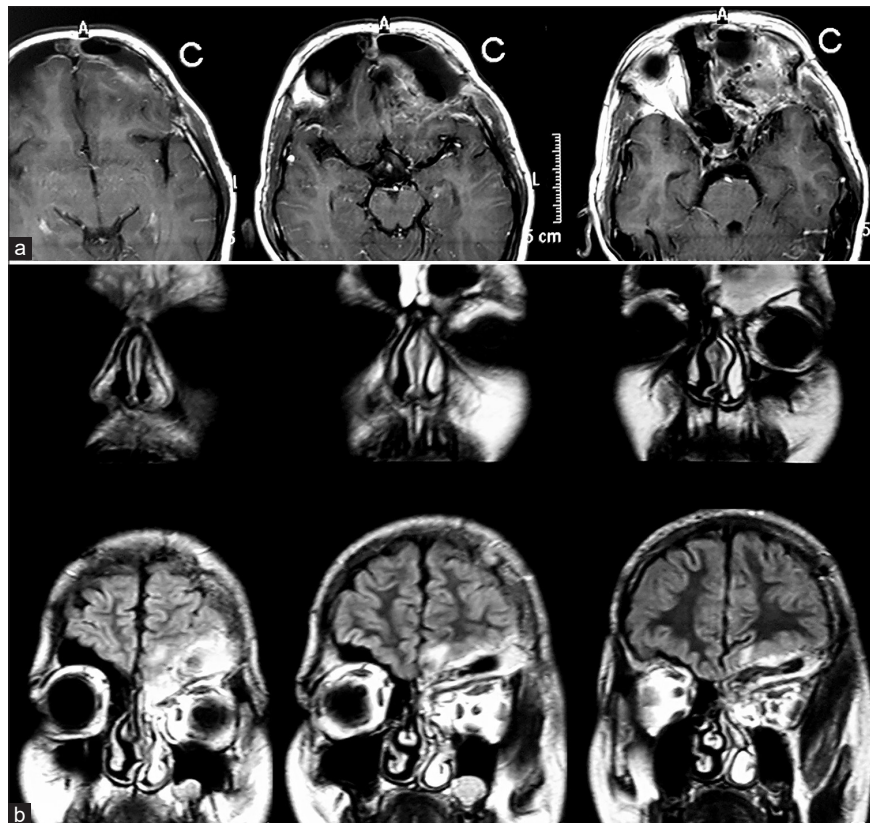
(a) Post-operative MRI Brain T1 post contrast axial section demonstrating interval resection of the lesion with resolution of mass effect and midline shift. (b) Post-operative MRI Brain post contrast FLAIR coronal images demonstrating the resection cavity extending to the midline.
